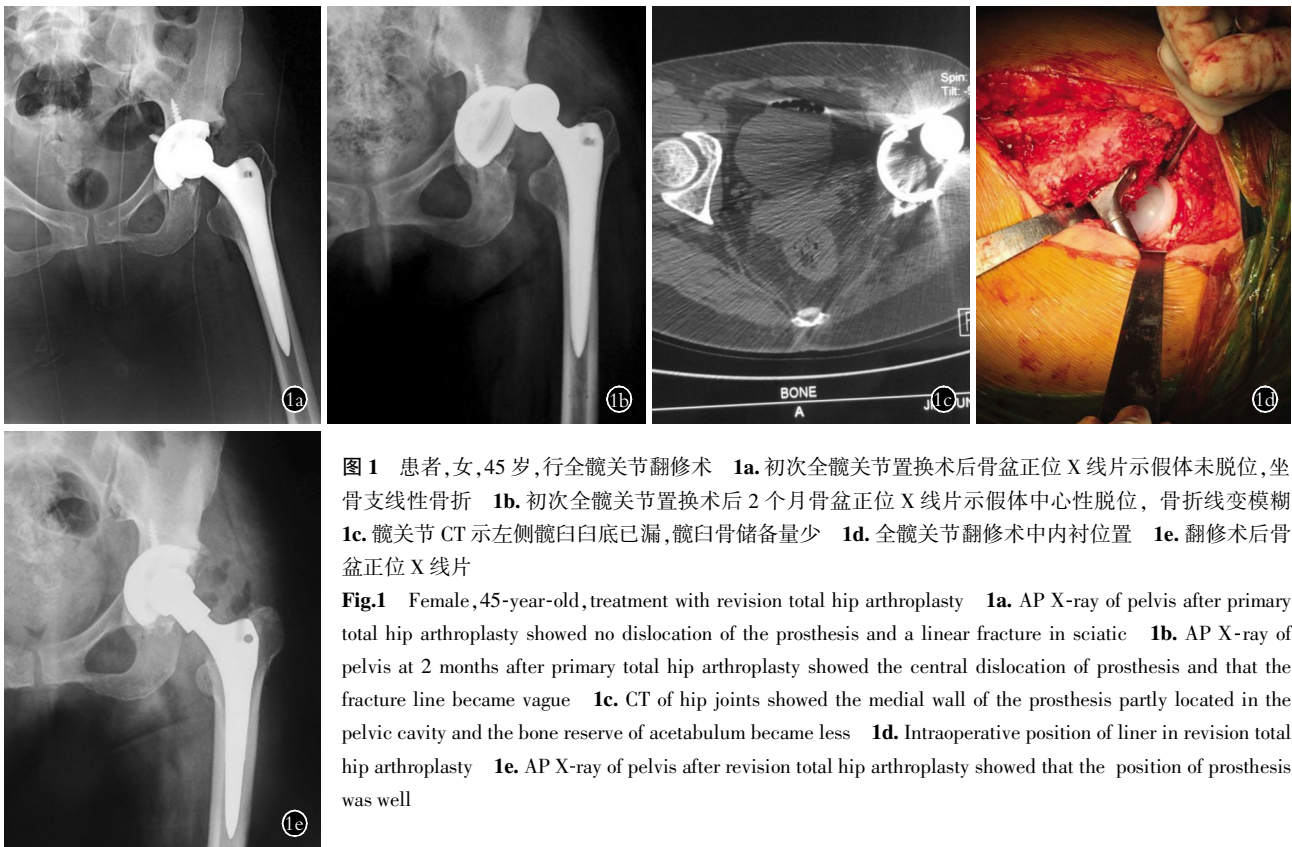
患者,女,45 岁,行全髋关节翻修术 1a. 初次全髋关节置换术后骨盆正位 X 线片示假体未脱位,坐骨支线性骨折 1b. 初次全髋关节置换术后 2 个月骨盆正位 X 线片示假体中心性脱位,骨折线变模糊 1c. 髋关节 CT 示左侧髋臼白底已漏,髋臼骨储备量少 1d. 全髋关节翻修术中内衬位置 1e. 翻修术后骨盆正位 X 线片
